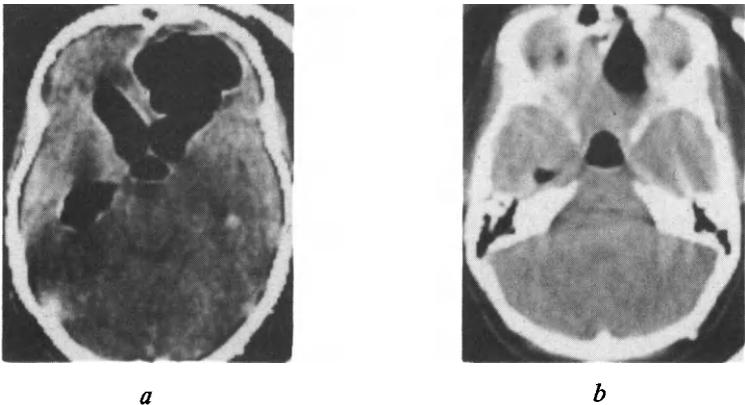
CSF rhinorrhea. Plain CT (a) at the level of the lateral and third ventricles; (b) wide window image at the level of the floor of the anterior fossa. There is air in the lateral and third ventricles which are dilated. An aerocoele extends from the frontal horn to expand the frontal lobe to a fracture which passes through the right frontal sinus. In this case the site of CSF rhinorrhea is evident from plain CT alone.
